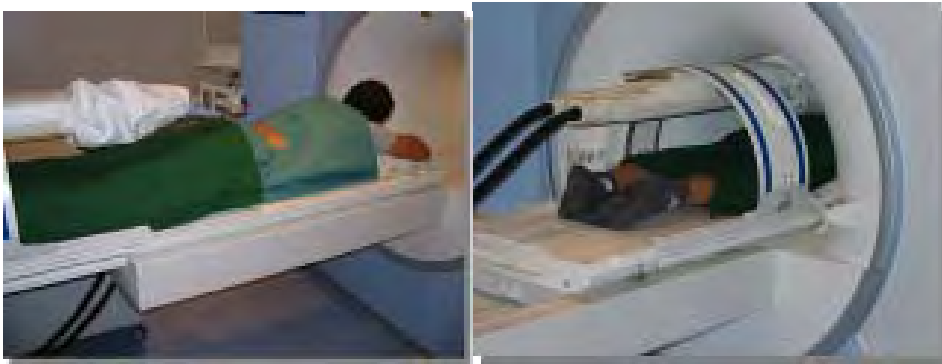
INNOMOTION robot for MRI-guided procedures
